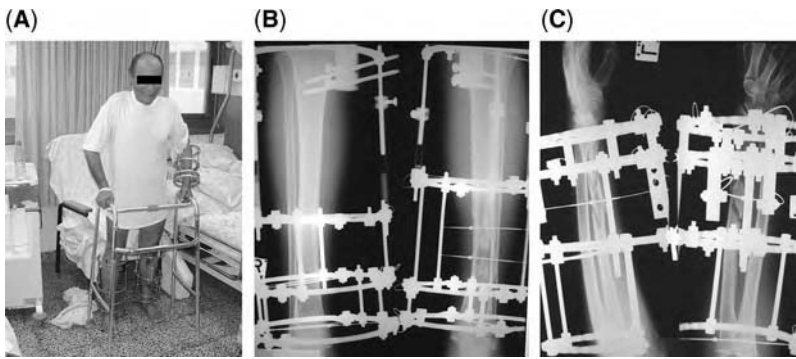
(A) Multiple trauma patient with fractures of both legs and left forearm. Of note, the patient is able to ambulate independently. (B) Postoperative X-ray of both legs after anatomic reduction. (C) Postoperative X-ray of left forearm after anatomic reduction.
